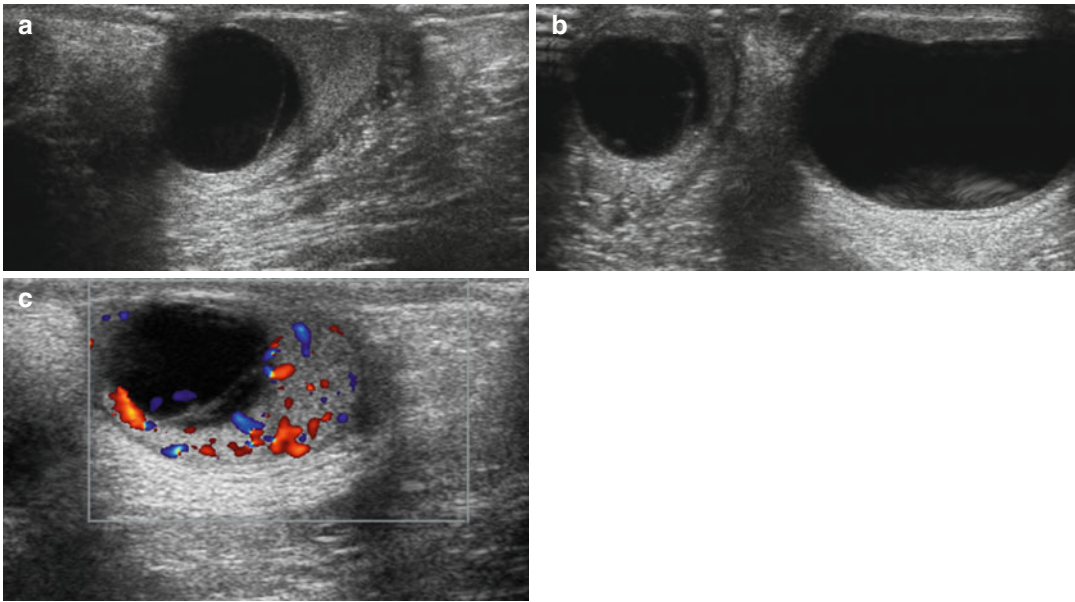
Ultrasound scans in case of testicular tumor; note the ovoid cystic bilateral mass (a, b), anechogenous and with inner hyperechoic solid septa and only peripheral color Doppler signal (c)
